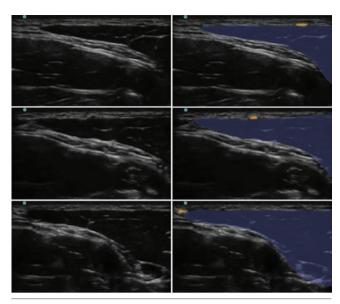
Image showing course of greater auricular nerve (GAN) from inferior (bottom image) to superior (top image) with unenhanced images on left and enhanced images on right. As the ultrasound probe is moved superiorly along the sternocleidomastoid (blue highlighting), the GAN (yellow highlighting) is best visualized passing from the lateral border of the muscle across its superficial surface in a medial direction.
